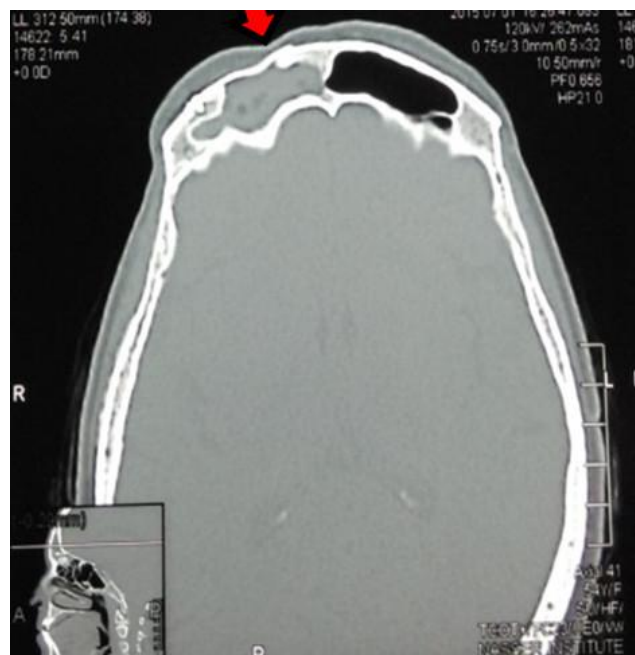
One year postoperative axial CT showing no evidence of complications, bone occupying lesions or infection, good maintenance of fat graft volume and complete frontal sinus obliteration after repair of the right frontal sinus cavity, and good drainage of the non-operated left side sinus cavity
